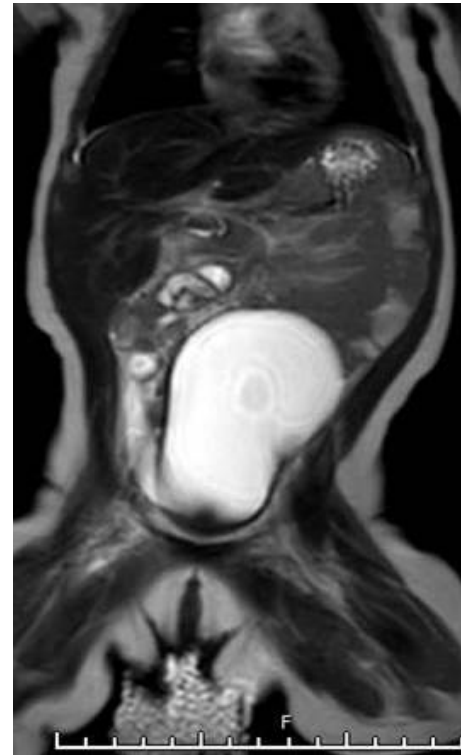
MRI T2W sagittal view showing 9.5 x 3.2 cm large, well defined, lobulated, craniocaudally elongated, pelvo-abdominal hydrometrocolpos; showing fluid signal with an inferiorly beaked orientation between the urethra anteriorly and rectum/anal canal posteriorly. The inferior extent of the beaked portion of the hydrometrocolpos was located at the level of inferior margin of pubic symphysis.
